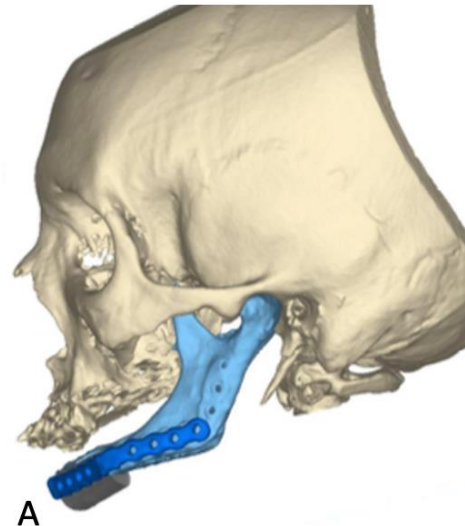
(A and B): Presurgical CT and postoperative computed tomography 6 months later.
